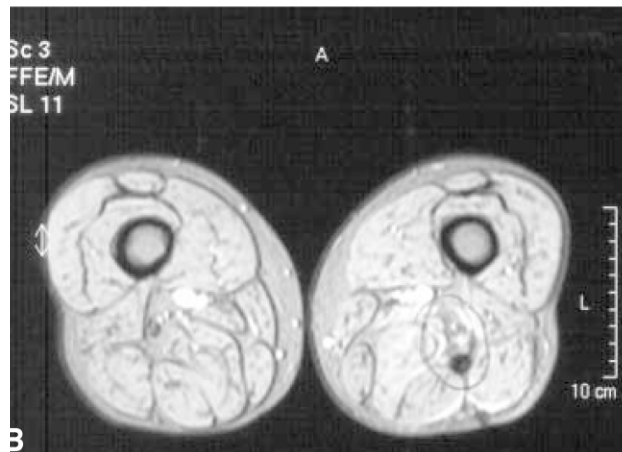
MRI 9 months postoperatively. The cyst did not recur. The patient was asymptomatic.
